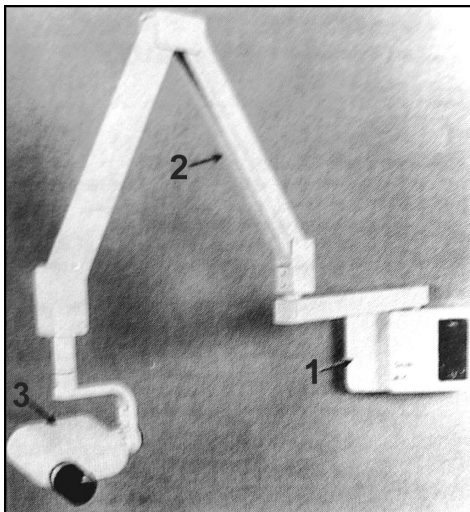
Three component parts of the dental X-ray machine
